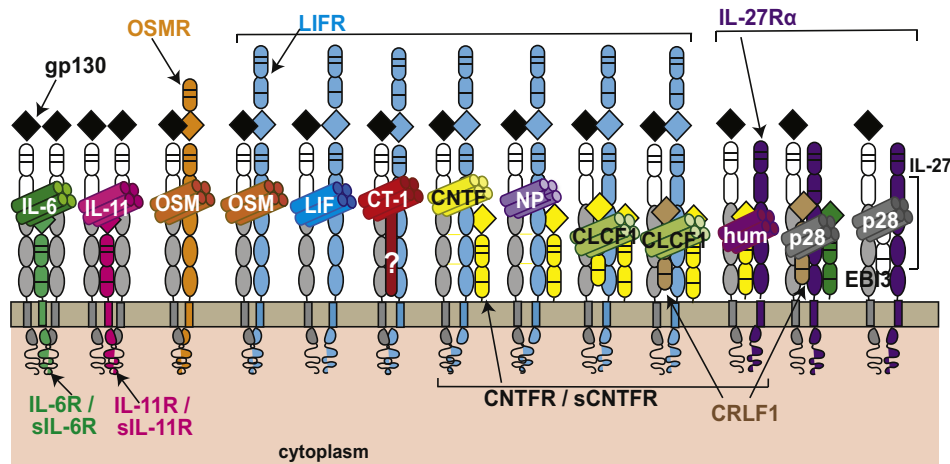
Cytokine receptor complexes formed by IL-6 family cytokines: Complexes are shown, left to right, in the order in which they are discussed in this chapter. gp130 is shown in gray on the left of each complex. IL-6 and IL-11 bind to ligand-specific β -receptor subunits (IL-6R and IL-11R, or their soluble counterparts, sIL-6R and sIL-11R, respectively) and complex with gp130 homodimers. The Oncostatin M (OSM) receptor (OSMR) is used by OSM, which then recruits gp130 to form a heterodimer. OSM also uses Leukemia inhibitory factor receptor (LIFR). LIFR is also used by LIF in a heterodimer with gp130. Cardiotrophin 1 (CT-1) also signals through LIFR and gp130 as well as, potentially, a CT-1-specific receptor subunit that remains undefined. Ciliary neurotrophic factor (CNTF) and neuropoietin (NP) signal through a complex containing LIFR, gp130 and either the membrane bound or soluble CNTF receptor (CNTFR or sCNTFR). Cardiotrophin-like cytokine factor 1 (CLCF1) acts as a compound cytokine either bound to sCNTFR or cytokine receptor-like factor (CRLF1), both of which bind to a gp130:LIFR:CNTFR multimer. Finally, three signaling complexes are shown that contain a heterodimer of gp130 and IL-27 α : humanin, which requires CNTFR, and p28, which can signal either as a gp130:IL-27 α complex containing CRLF1 and the IL-6 receptor, or as IL-27, in complex with gp130:IL-27 α and EB13. For simplicity, soluble receptors are not pictured.
